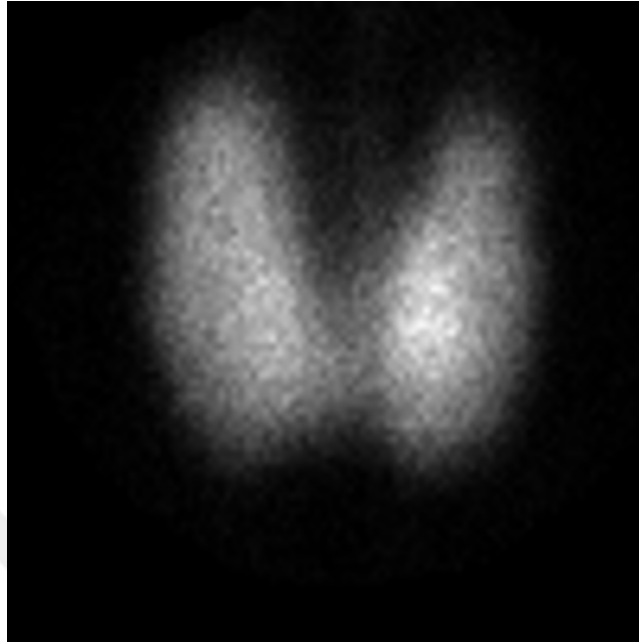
Demonstration of scintigraphic diffuse homogenous uptake image
